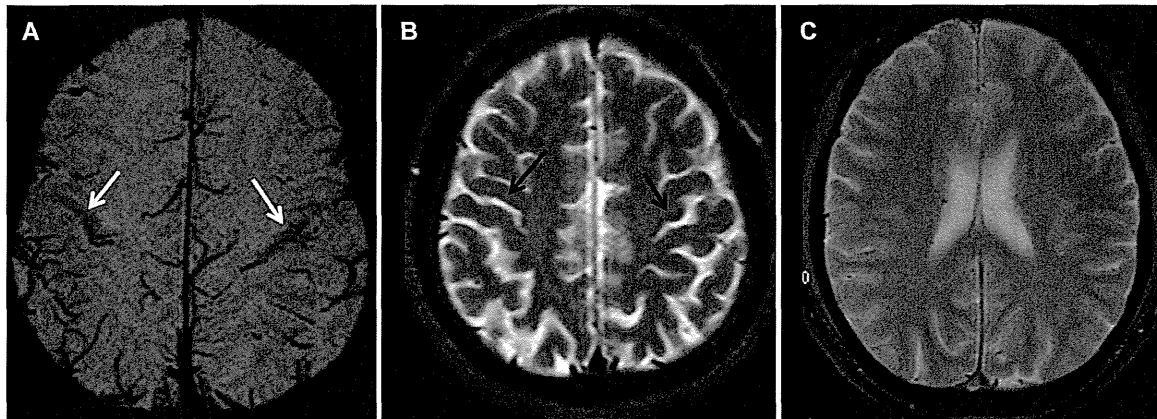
(A) Axial SWI (minlp) of a superior slice shows markedly low signal intensity in bilateral precentral cortices compared to the superior frontal cortices (Score 2) and moderately hypointense on the right side (white arrow) compared to the superior frontal cortex (Score 1). (B) Axial conventional T2-weighted image of a superior slice shows mildly low intensity in bilateral precentral cortices compared to the superior frontal cortices of the same slice (Score 1). (C) Axial T2*-weighted image of superior slice appears isointense compared to superior frontal cortices (Score 0).
